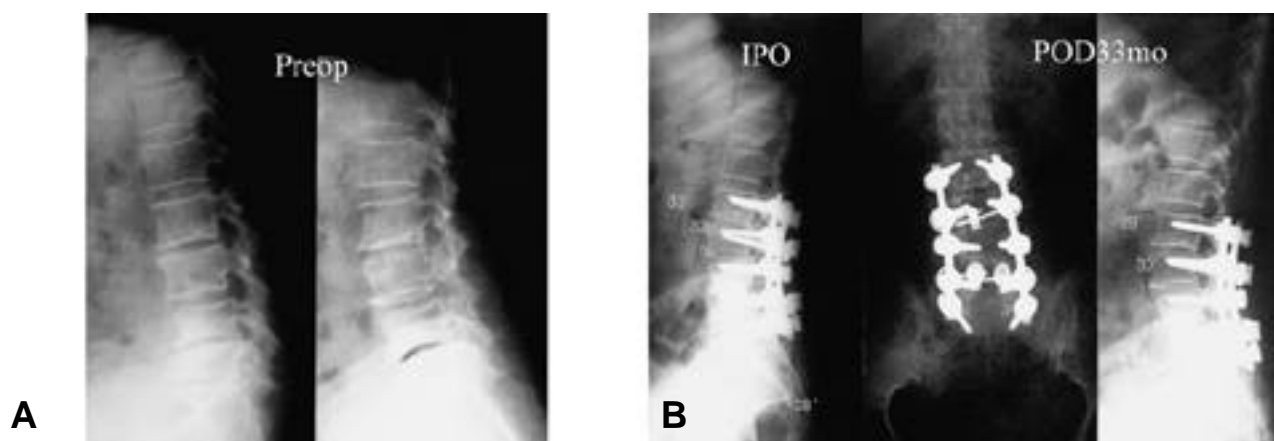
Preoperative lateral radiography of 66-year-old woman shows disc degeneration of L2-3 L4-5 L5-S1, wedge vertebrae L5 and pseudospondylolisthesis L3 on 4.
